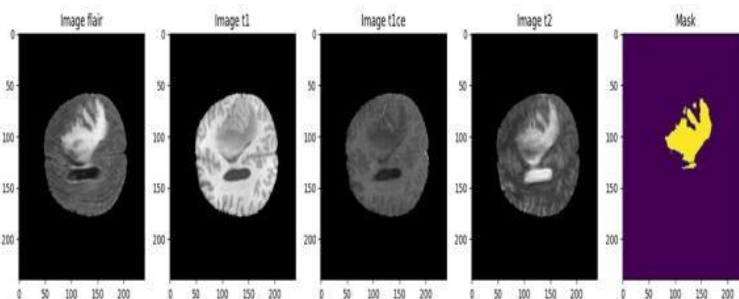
VISUAL REPRESENTATION OF AN MRI IMAGE
